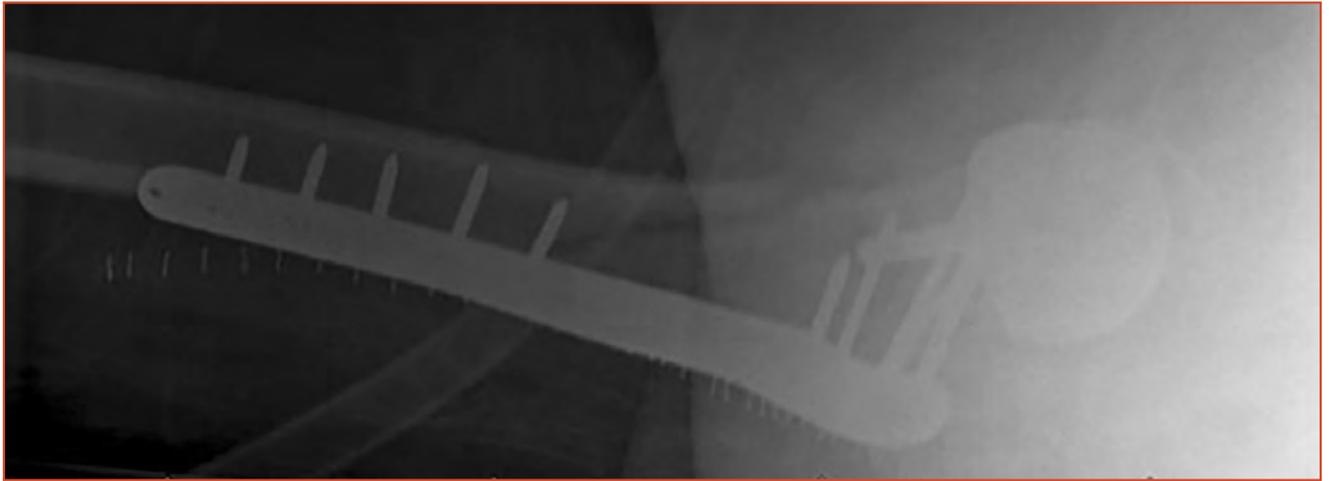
Immediate postoperative anteroposterior radiograph of the right femur, showing a well-reduced fracture with a lateral proximal femoral locking plate in place.
